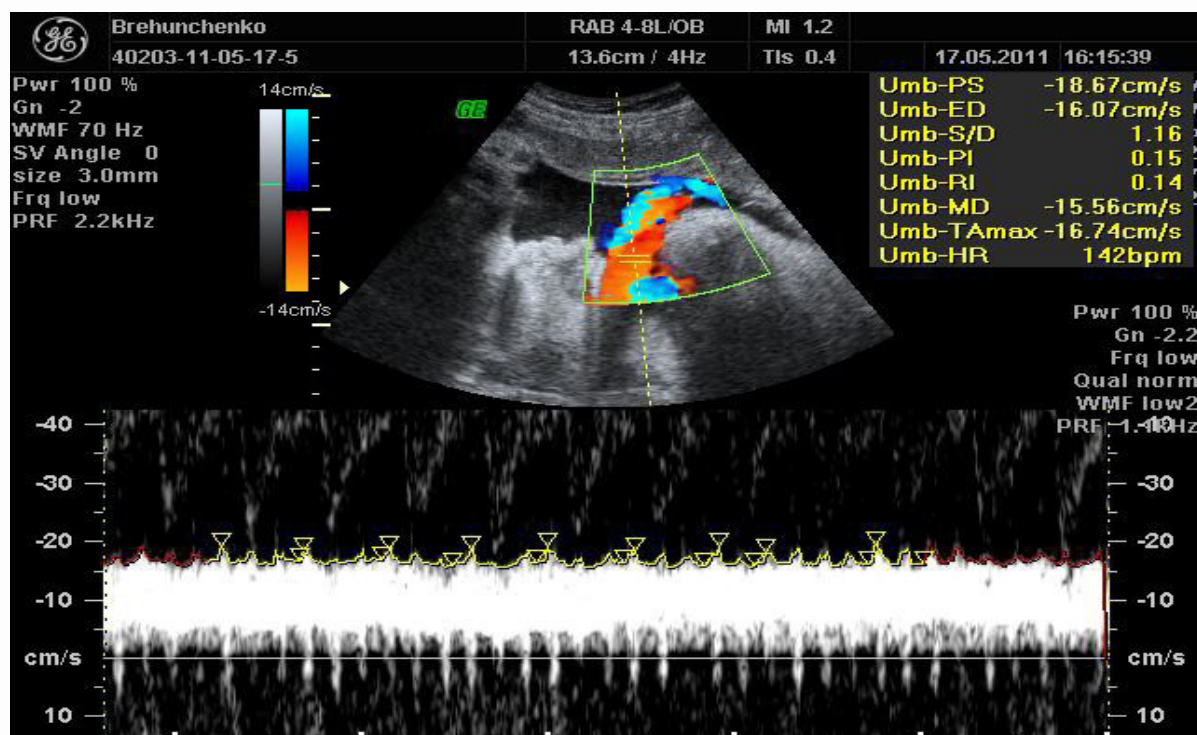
Doppler venous umbilical hemodynamics in normal pregnancy (the peaks of fluctuations are indicated by arrows).
